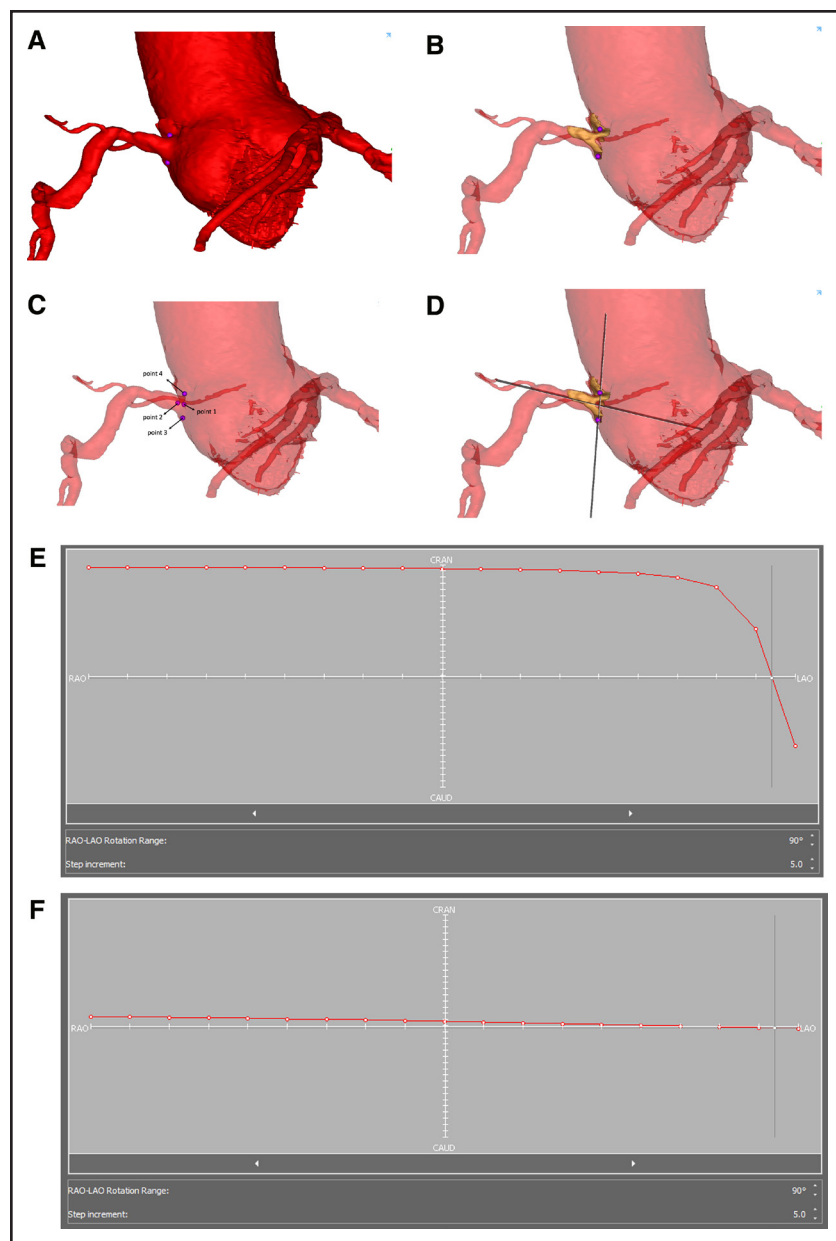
Three-dimensional (3D) computed tomography analysis.
